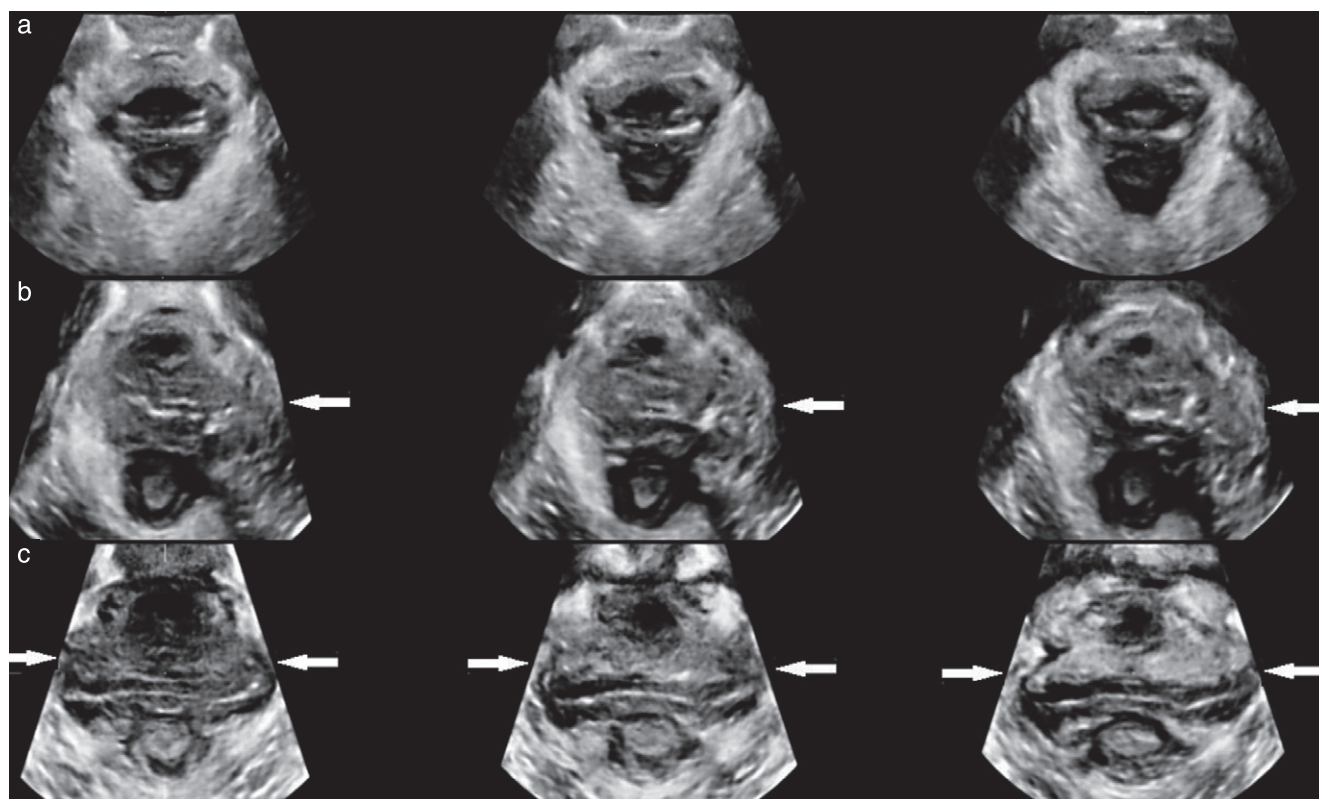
Three central slices on tomographic ultrasound imaging, showing intact levator (a), unilateral avulsion (b) and bilateral avulsion (c). Avulsion is indicated by arrows.
